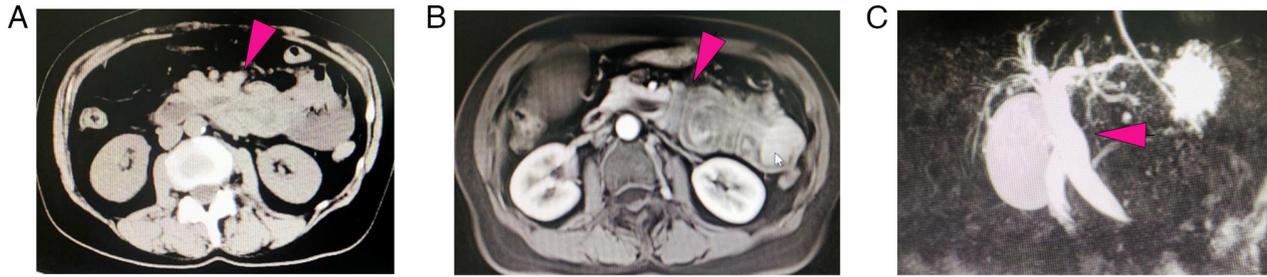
Intussusception of the initial jejunum according to CT and MRI. (A) Intussusception of the initial jejunum (arrow) observed by CT. (B) Intussusception of the initial jejunum (arrow) observed by MRI. (C) Magnetic resonance cholangiopancreatography revealing an enlarged and displaced common bile duct (arrow). CT, computed tomography; MRI, magnetic resonance imaging.
